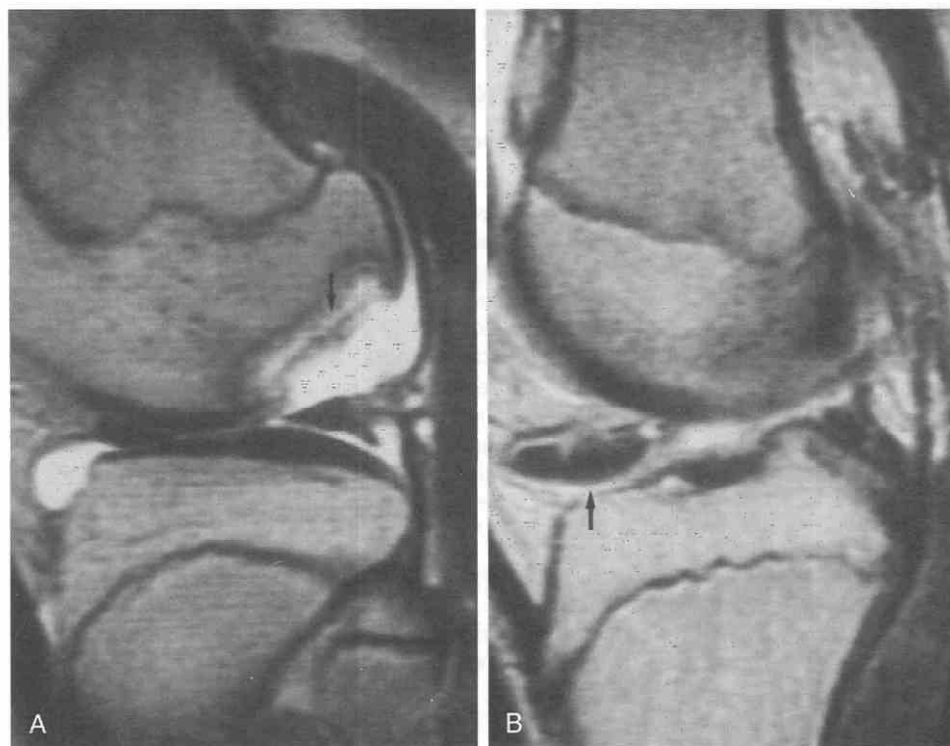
Displaced osteochondral fracture. *A*, Sagittal T2-weighted image shows a large osteochondral defect at the posterior aspect of the lateral femoral condyle (*arrow*). A large joint effusion is present. *B*, Sagittal T2-weighted image more centrally shows the detached bony fragment anteriorly (*arrow*). The low signal intensity of the fragment is suggestive of secondary osteonecrosis.
